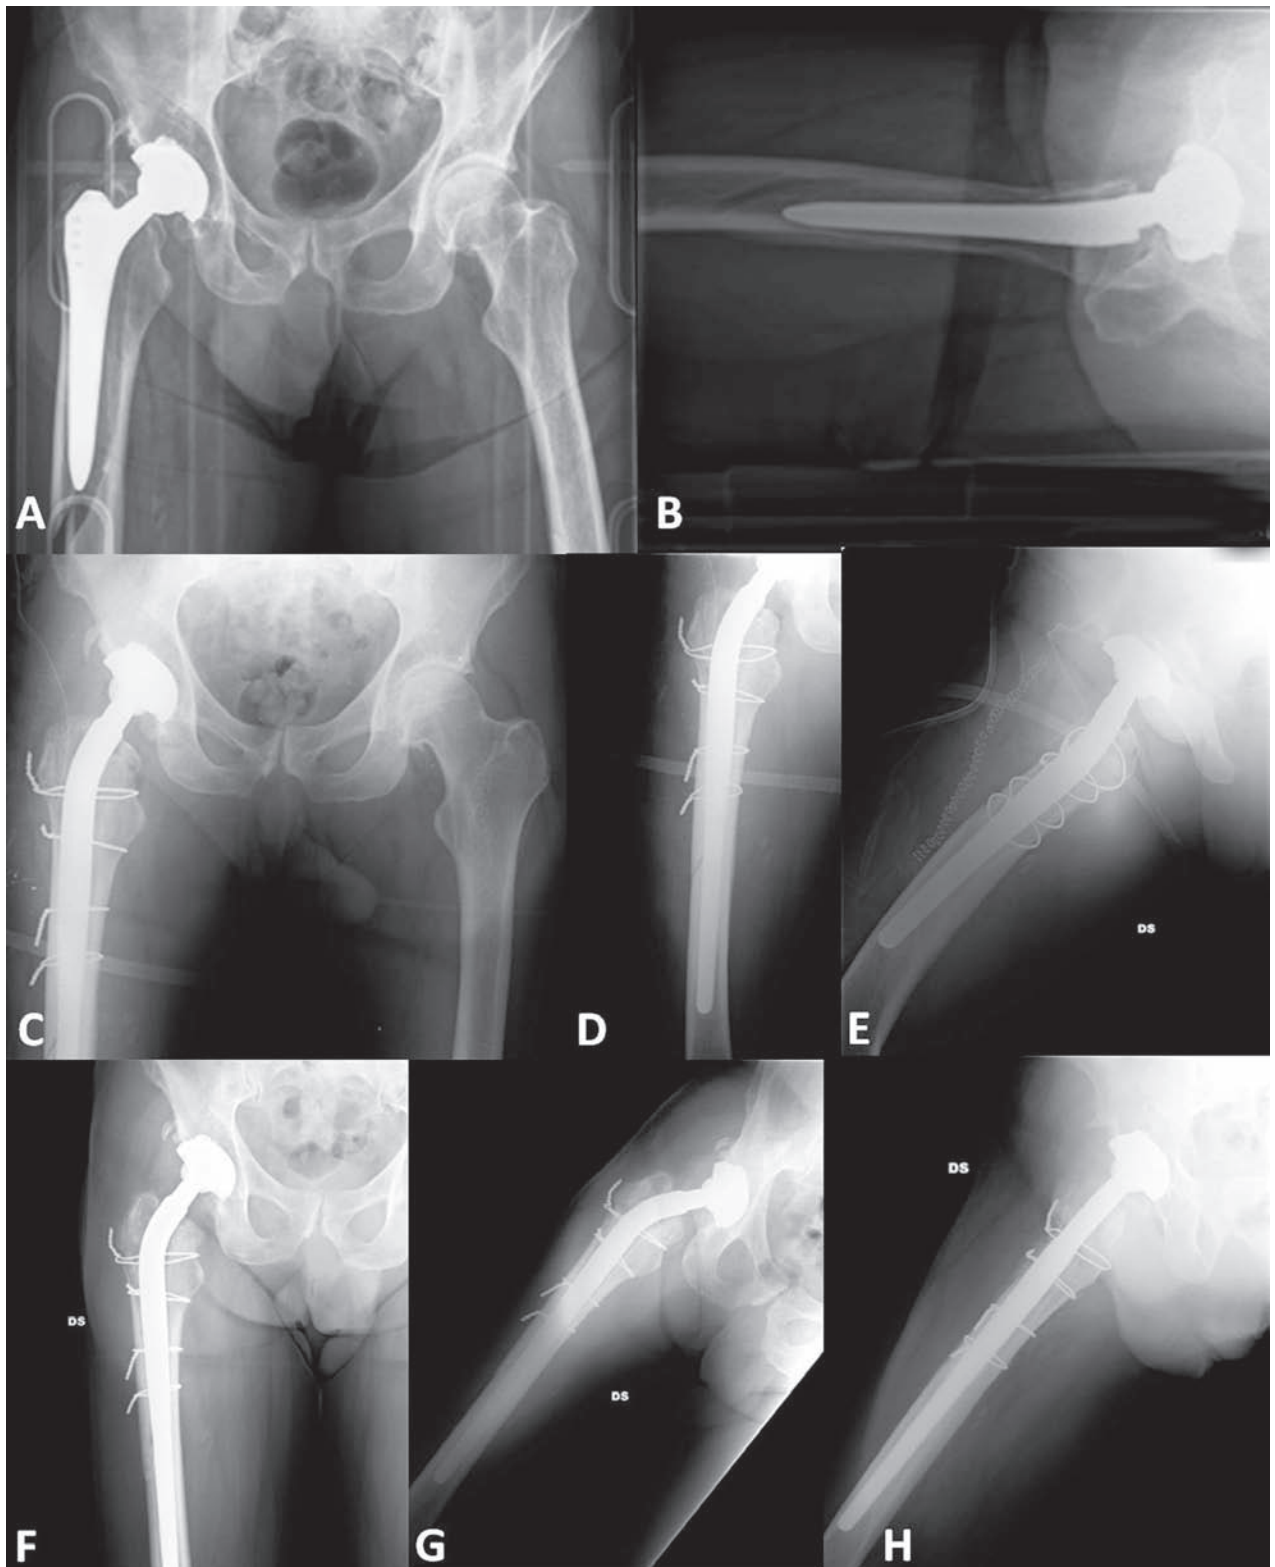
Type B3 right periprosthetic fracture. A and B; preoperative x-rays. C, D and E; postoperative x-ray after revision of the stem and positioning of 4 metallic cables. F, G and H; x-ray 24 months after trauma with fracture consolidated.
